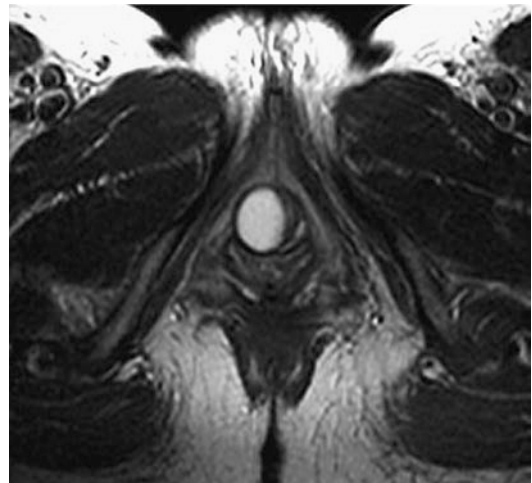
Urethral Diverticulum. T2 weighted axial MRI, showing a fluid filled spherical lesion anterior to vaginal vault. Clinical and endoscopic examination revealed a small communication with the intra-sphincteric urethra, consistent with a urethral diverticulum
